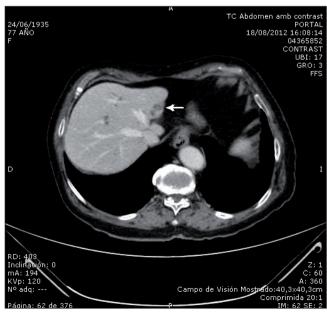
Abdominal CT scan. Left hepatic lobe atrophy, dilated bile duct at this level (arrow).
